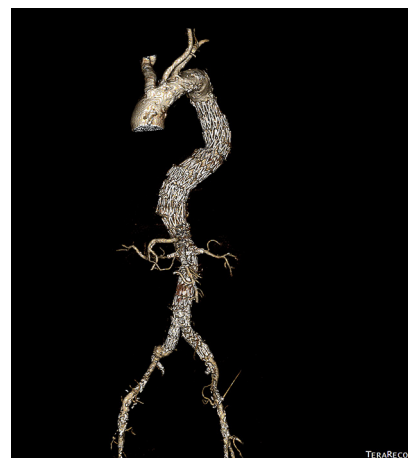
Three dimensional volume rendering reconstruction of the post-operative computed tomography following urgent fenestrated repair.
